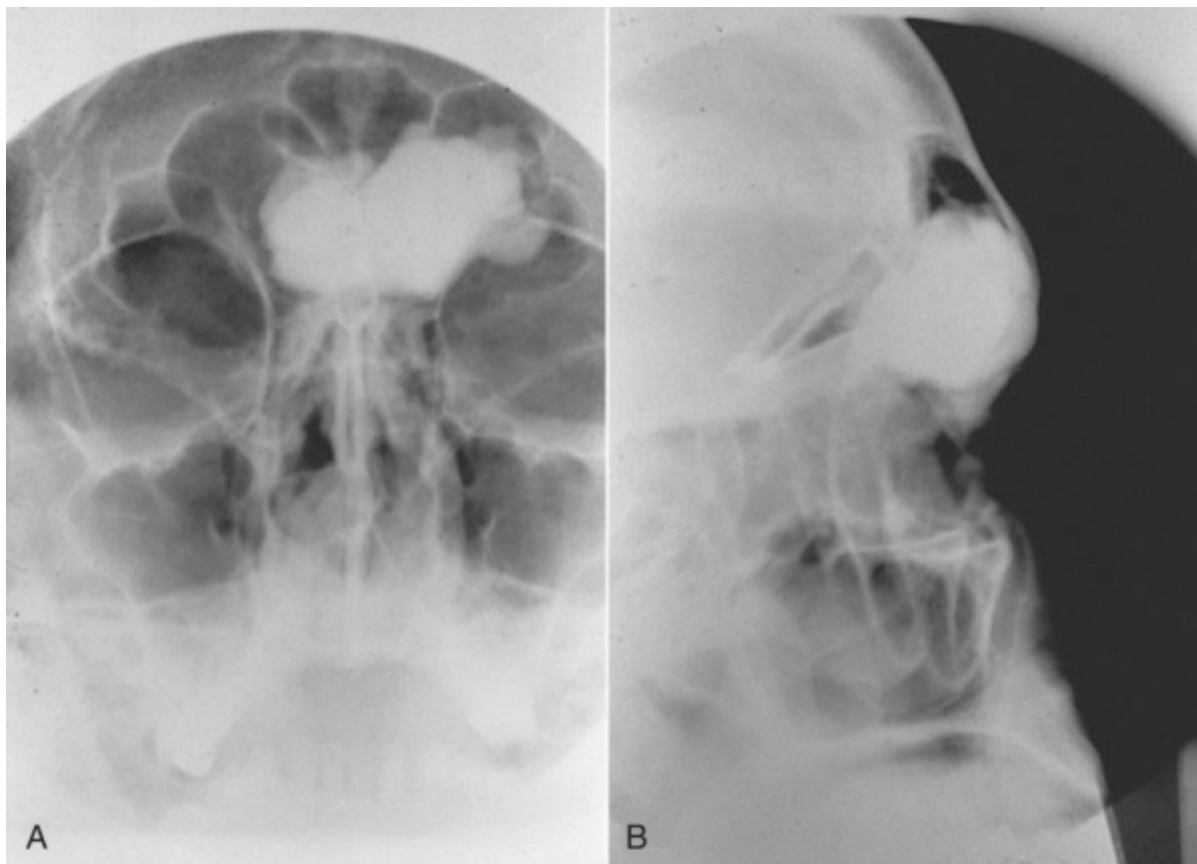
A, Anteroposterior radiograph demonstrating a large osteoma of the frontal sinus. B, Lateral radiograph confirming the position of the osteoma in the frontal sinus. This lesion was deemed inappropriate for endoscopic removal, and an open procedure through an osteoplastic flap was performed.
